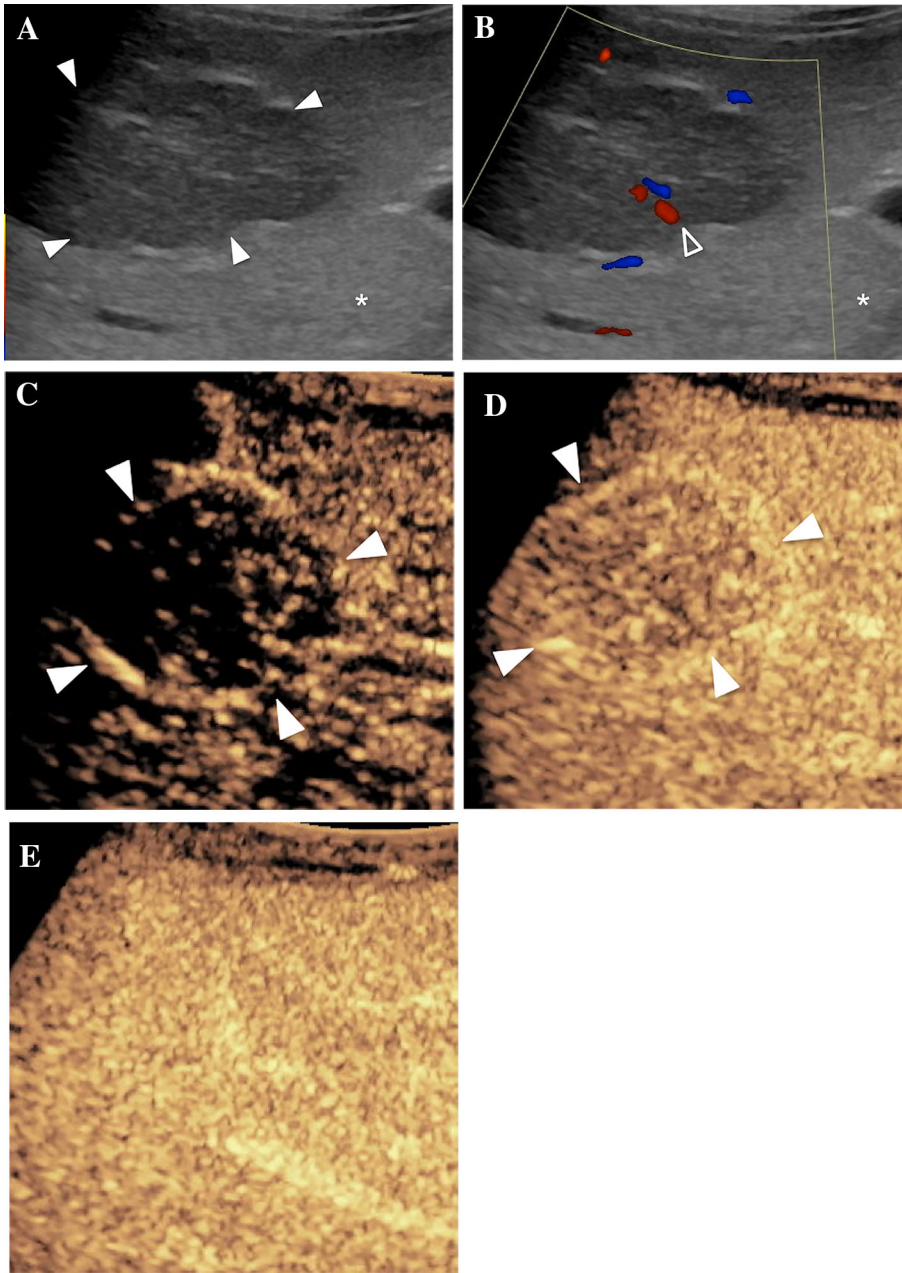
IV CEUS. Focal Fatty Sparring. 1.5-year-old boy referred for ultrasound evaluation of clinically suspected hepatosplenomegaly, hepatitis, and cholestasis. A Baseline gray scale ultrasound. A geographic, relative hypoechoic area (solid arrowheads) is noted in the right hepatic lobe. B On Color Doppler imaging, normal vessels are seen coursing through this area (open arrowhead). The remaining liver is relatively hyperechoic suggestive of fatty liver (asterisk). C--E Contrast-enhanced Ultrasound. Following intravenous injection of the ultrasound contrast agent, there is slight delay in opacification of the large geographic hypoechoic lesion. The remaining vascular phases show similar enhancement characteristics as the adjacent liver. Overall, these are benign enhancement features. This region represents an area of focal fatty sparing in an otherwise fatty liver. No other investigation performed.
